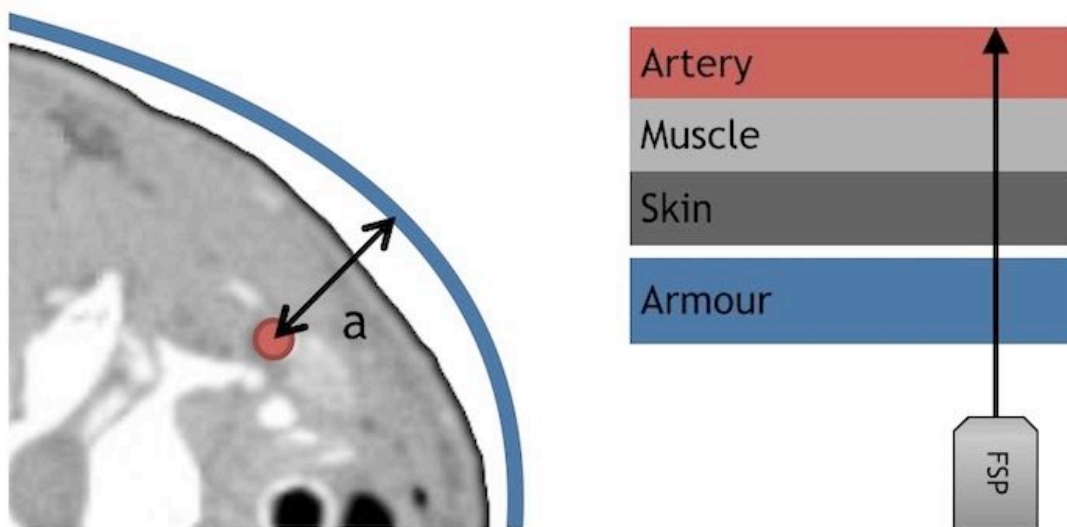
Critical distance to damage (label a) for FSP perforating the ballistic protective material demonstrated on an axial CT slice.
